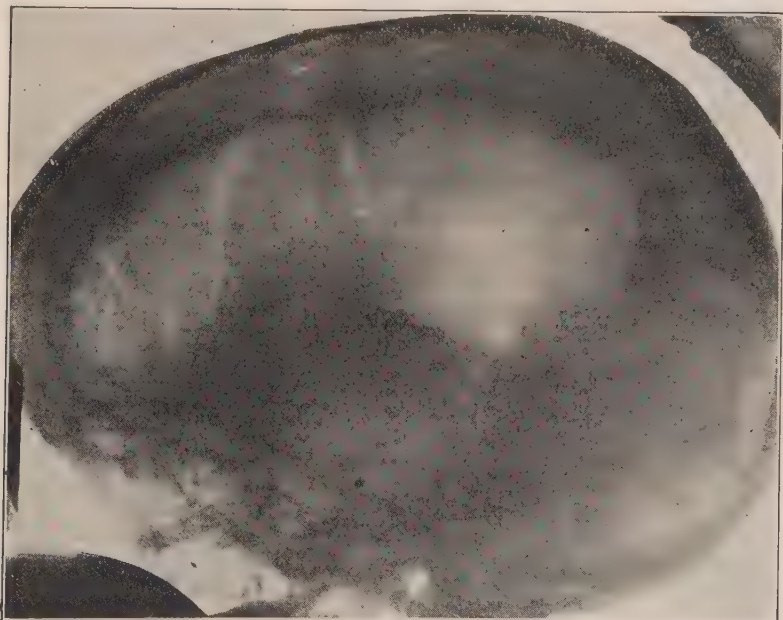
SKULL IN CHONDRODYSTROPHY. Showing hydrocephalus—x-ray after ventricles are distended with air (Dandy).
